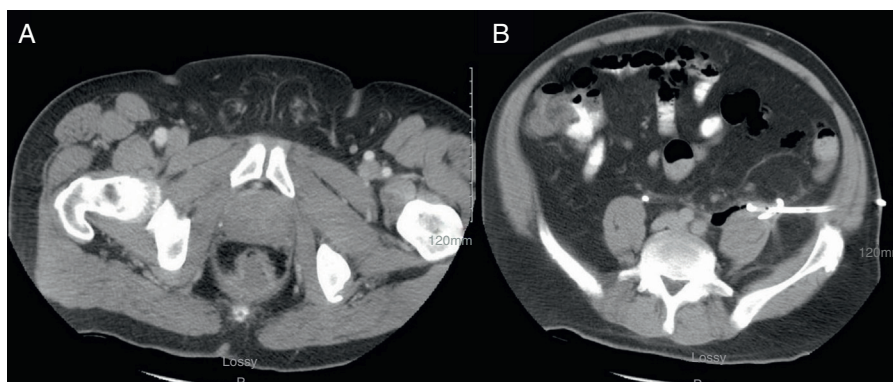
CT scan 15 days (post-operative day 22) after CT guided percutaneous drain placement demonstrating resolved peri-rectal (A) and retroperitoneal abscesses (B).
